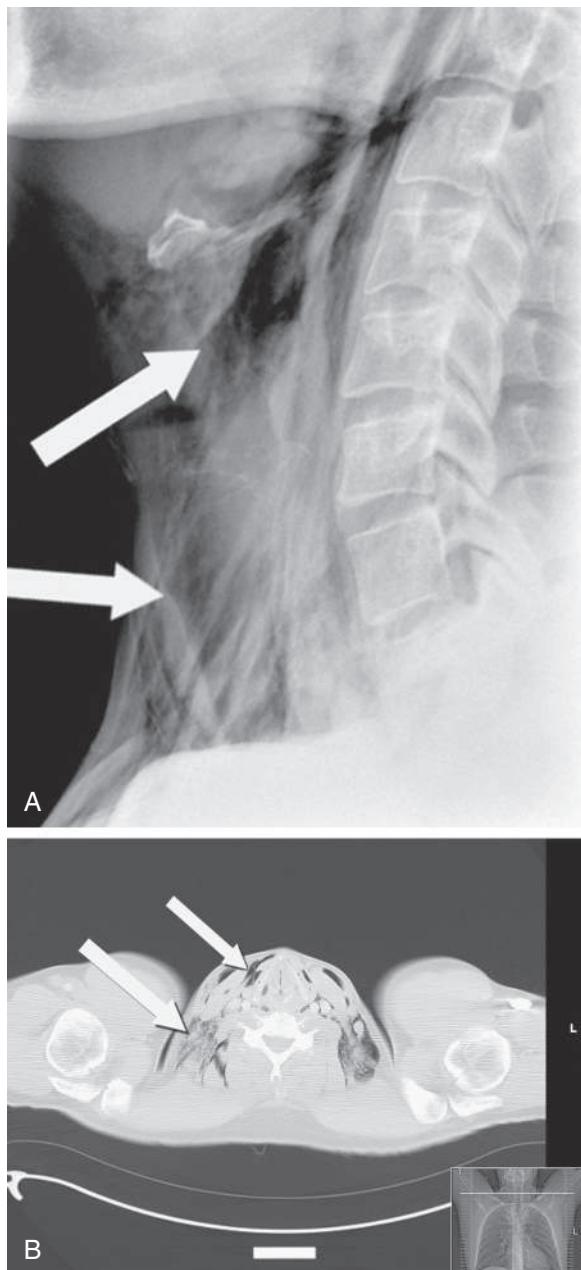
A, Lateral x-ray of neck showing subcutaneous emphysema. B, Axial section CT neck/thorax showing subcutaneous emphysema and pneumomediastinum. (From Zakaria R, Khwaja H. Subcutaneous emphysema in a case of infective sinusitis: a case report. J Med Case Rep. 2010;4:235, Figs. 1 and 2.)
